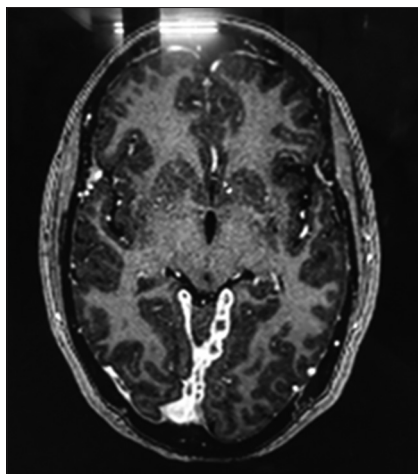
Magnetic resonance imaging of the brain with contrast suggestive of leptomeningeal enhancement and ring-enhancing lesion
